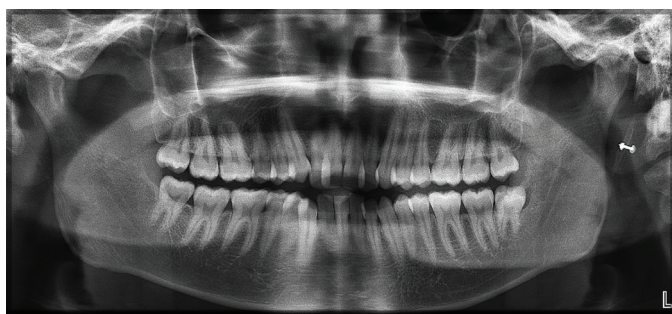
Preoperative panoramic radiograph showing a distally impacted mandibular left third molar.
